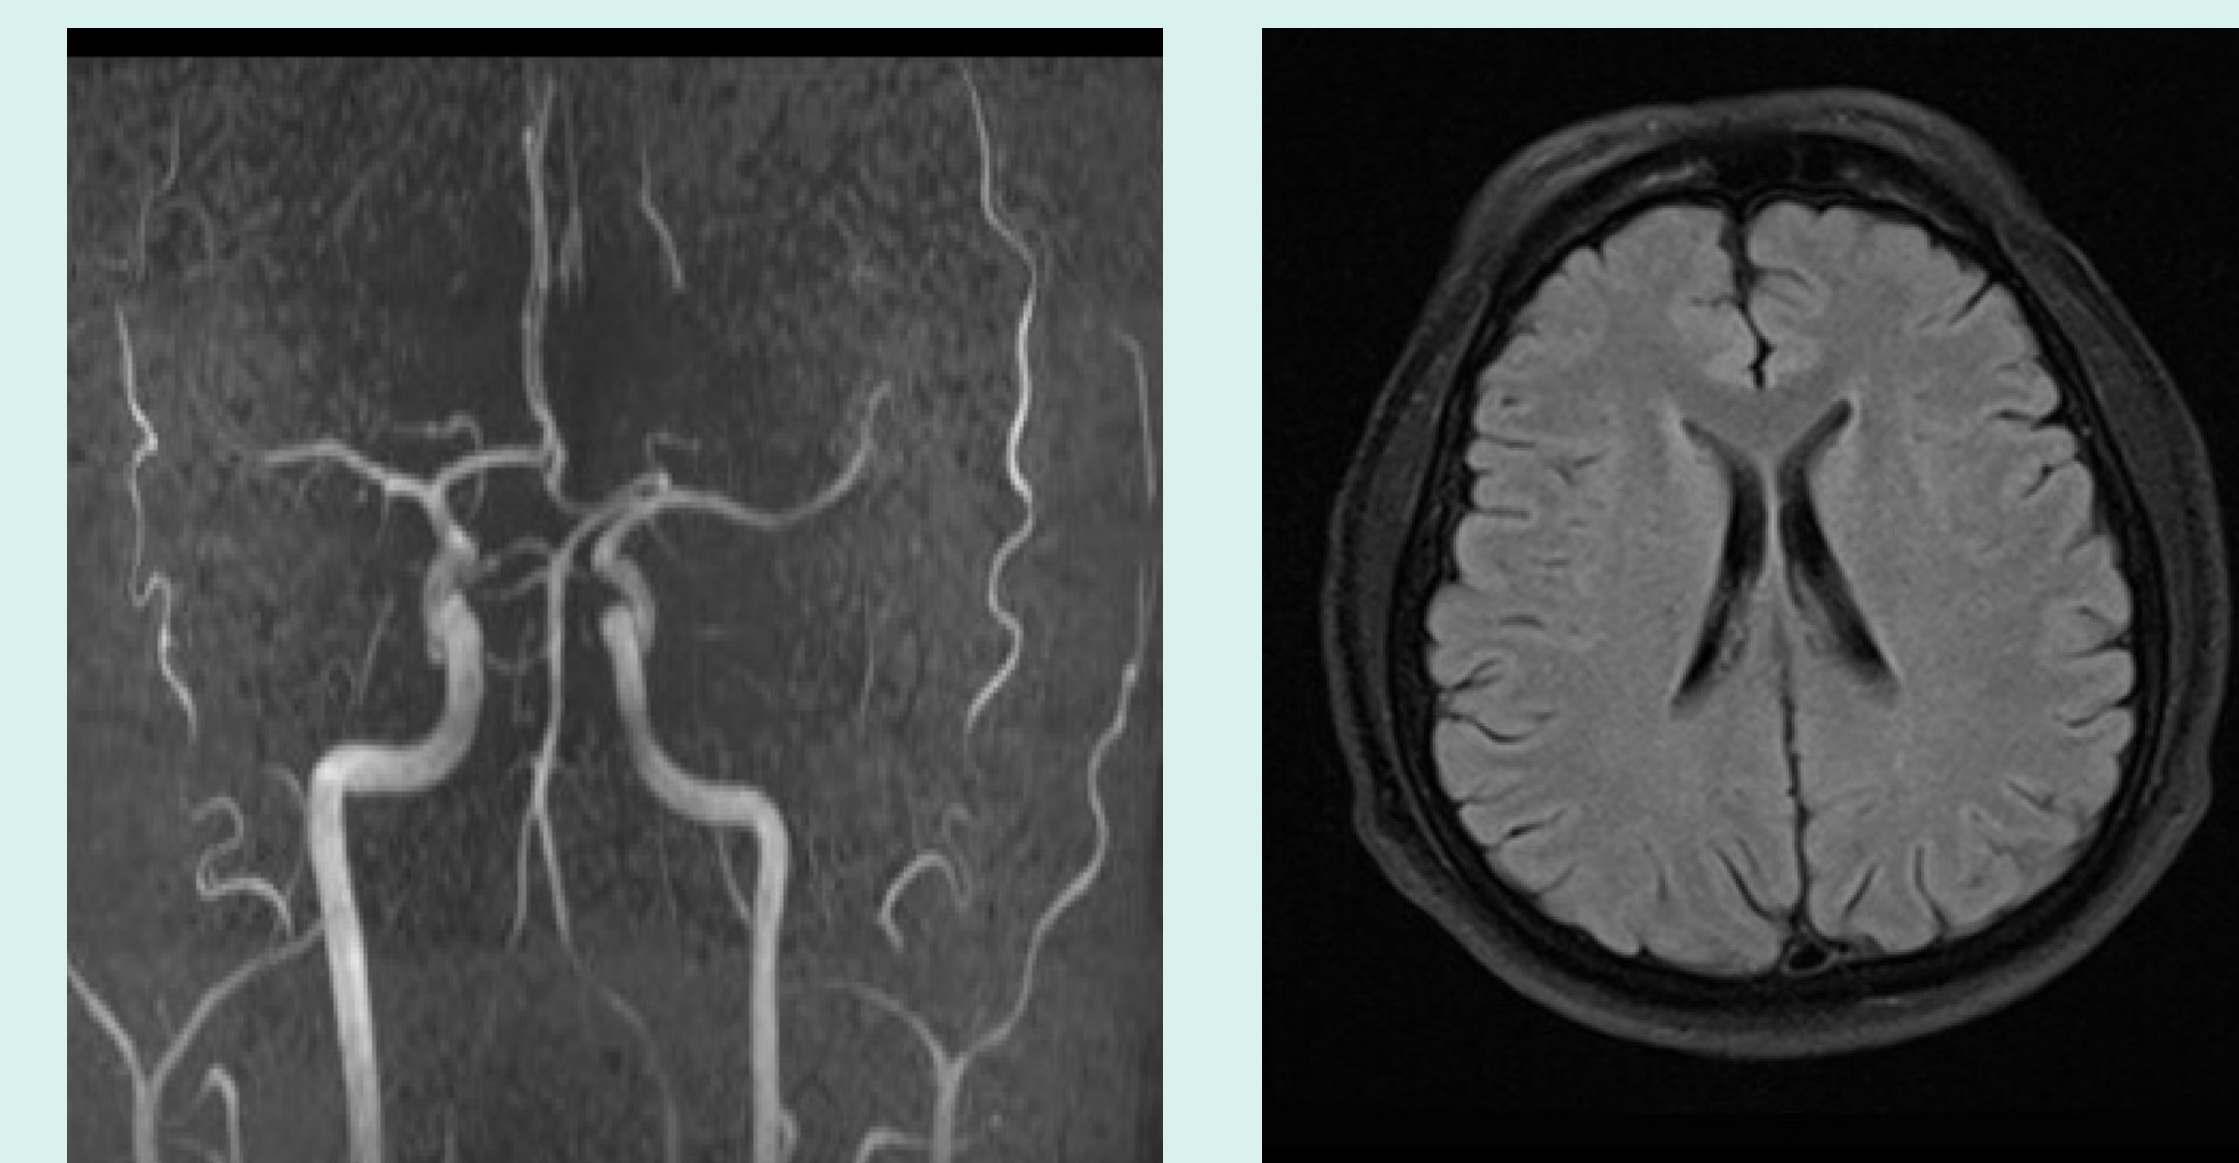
Normal brain MRI/MRA ruled out acoustic neuroma, neurosyphilis, or CVA
